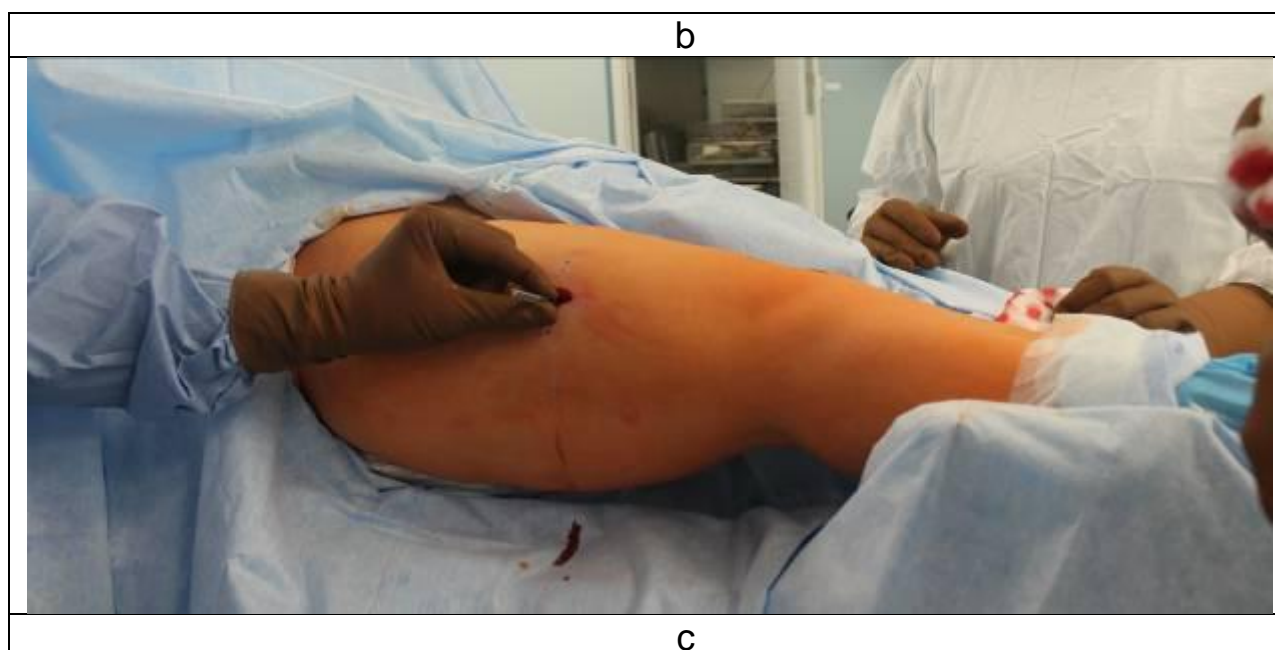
Insertion of SUV-clamp: the handle of Instrument #2 is turned for 90 degrees from the initial position
